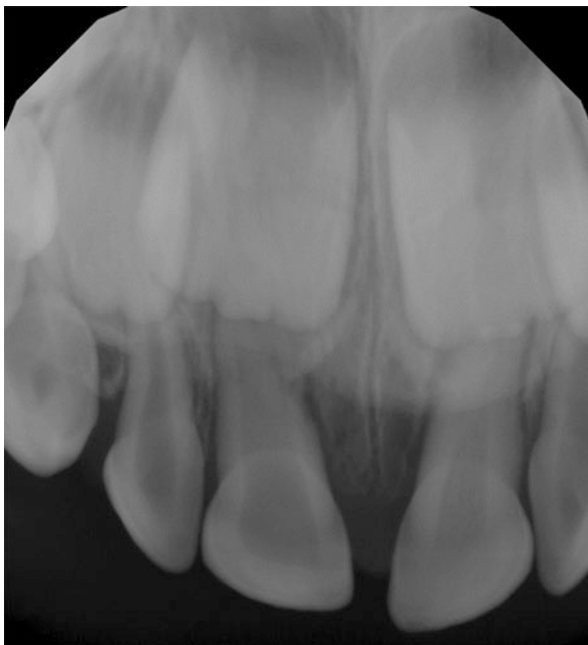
This periapical radiograph was taken with a solid-state sensor to verify the primary maxillary central incisors after a trauma that occurred 3 weeks before. The right-hand-side primary central incisor was clinically gray. The radiograph shows a widened pulp system in that tooth, indicating that the tooth had suffered at least one other trauma sometime before the last one 3 weeks ago. A slightly widened periodontal ligament space was observed on both primary central incisors. Careful examination and interpretation of the radiograph are necessary to put the radiographic findings of the pulp canals and the clinical appearance into perspective
